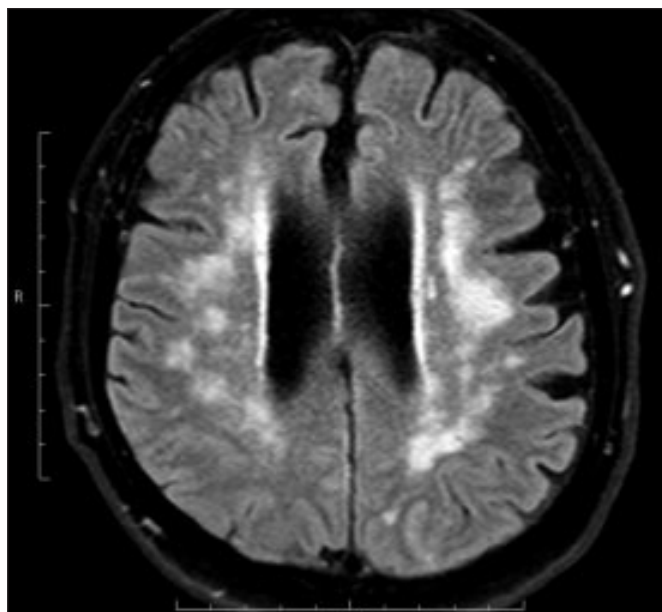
Axial FLAIR brain image with periventricular white matter changes with early confluent pattern.
